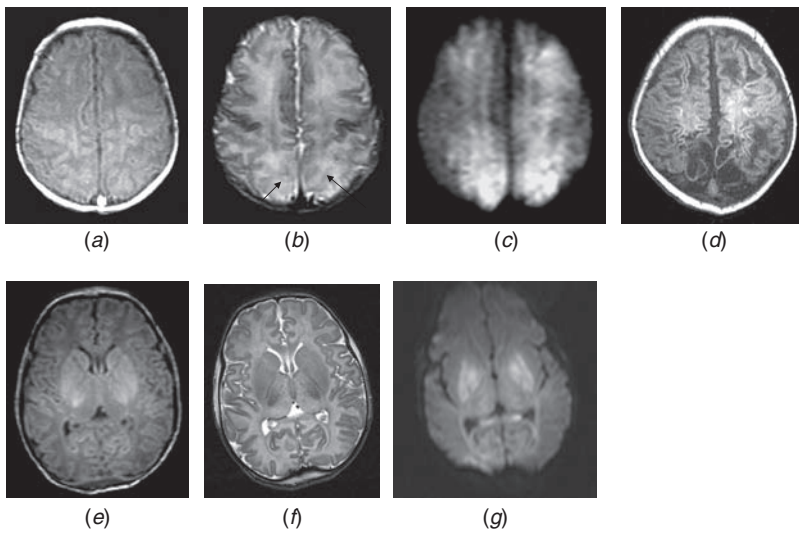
Diffusion-weighted imaging ([DWI] Rutherford, 2002).
